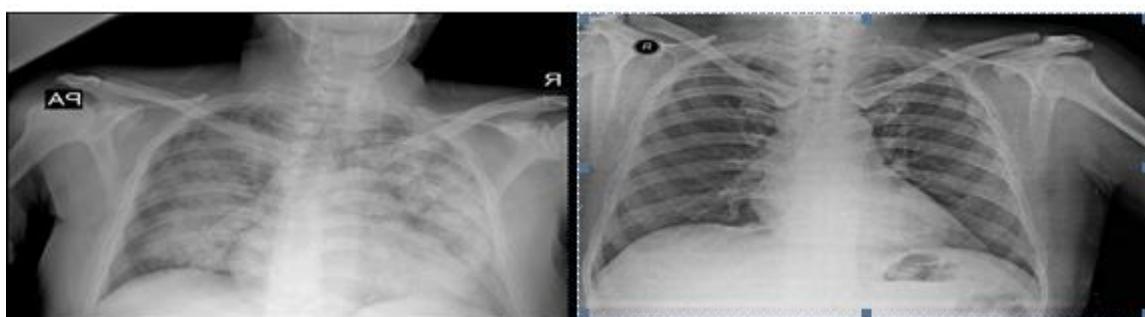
Chest X-Rays Of The Patient During Dah (A) And After Treatment (B).
